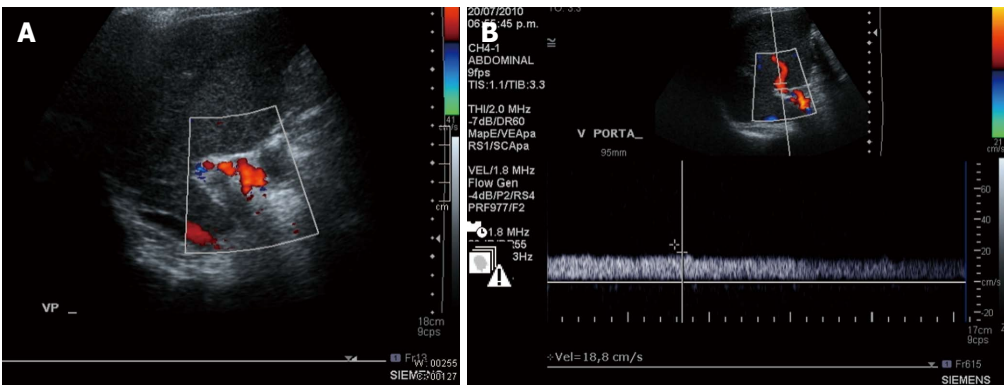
Doppler ultrasound. A: Liver Doppler ultrasound. The image shows the thrombus in the portal vein; B: Doppler ultrasound, performed 4 mo after discharge, revealed that the portal vein thrombi had disappeared and a smooth bloodstream was observed in the portal vein.
